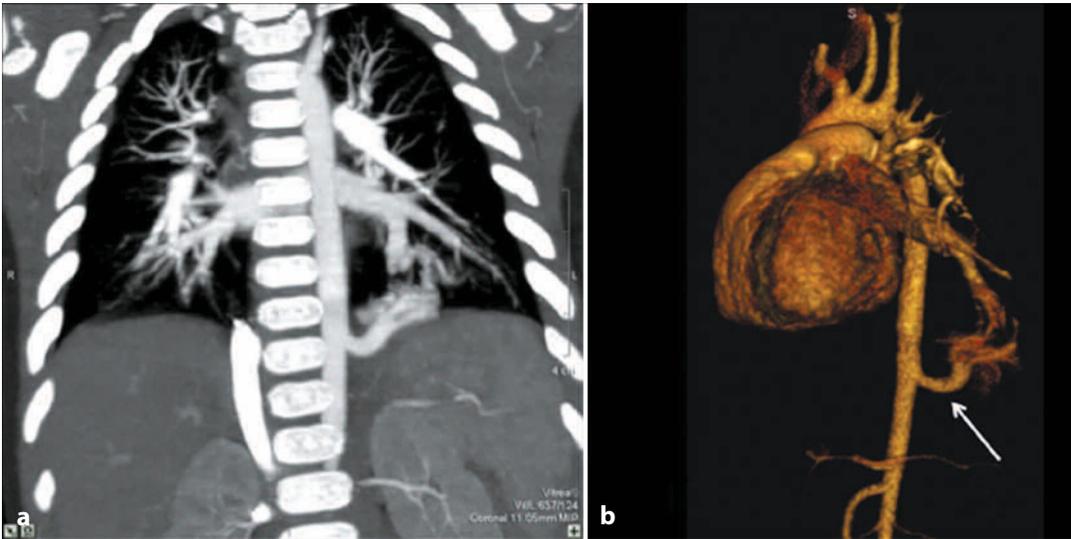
Angio CT in a patient with a left basal IBPS. An ectopic arterial supply from the aorta and venous drainage to the pulmonary veins is readily visible (a). Reconstruction of the arterial supply (*arrow*) greatly facilitates the surgical strategy (b)
